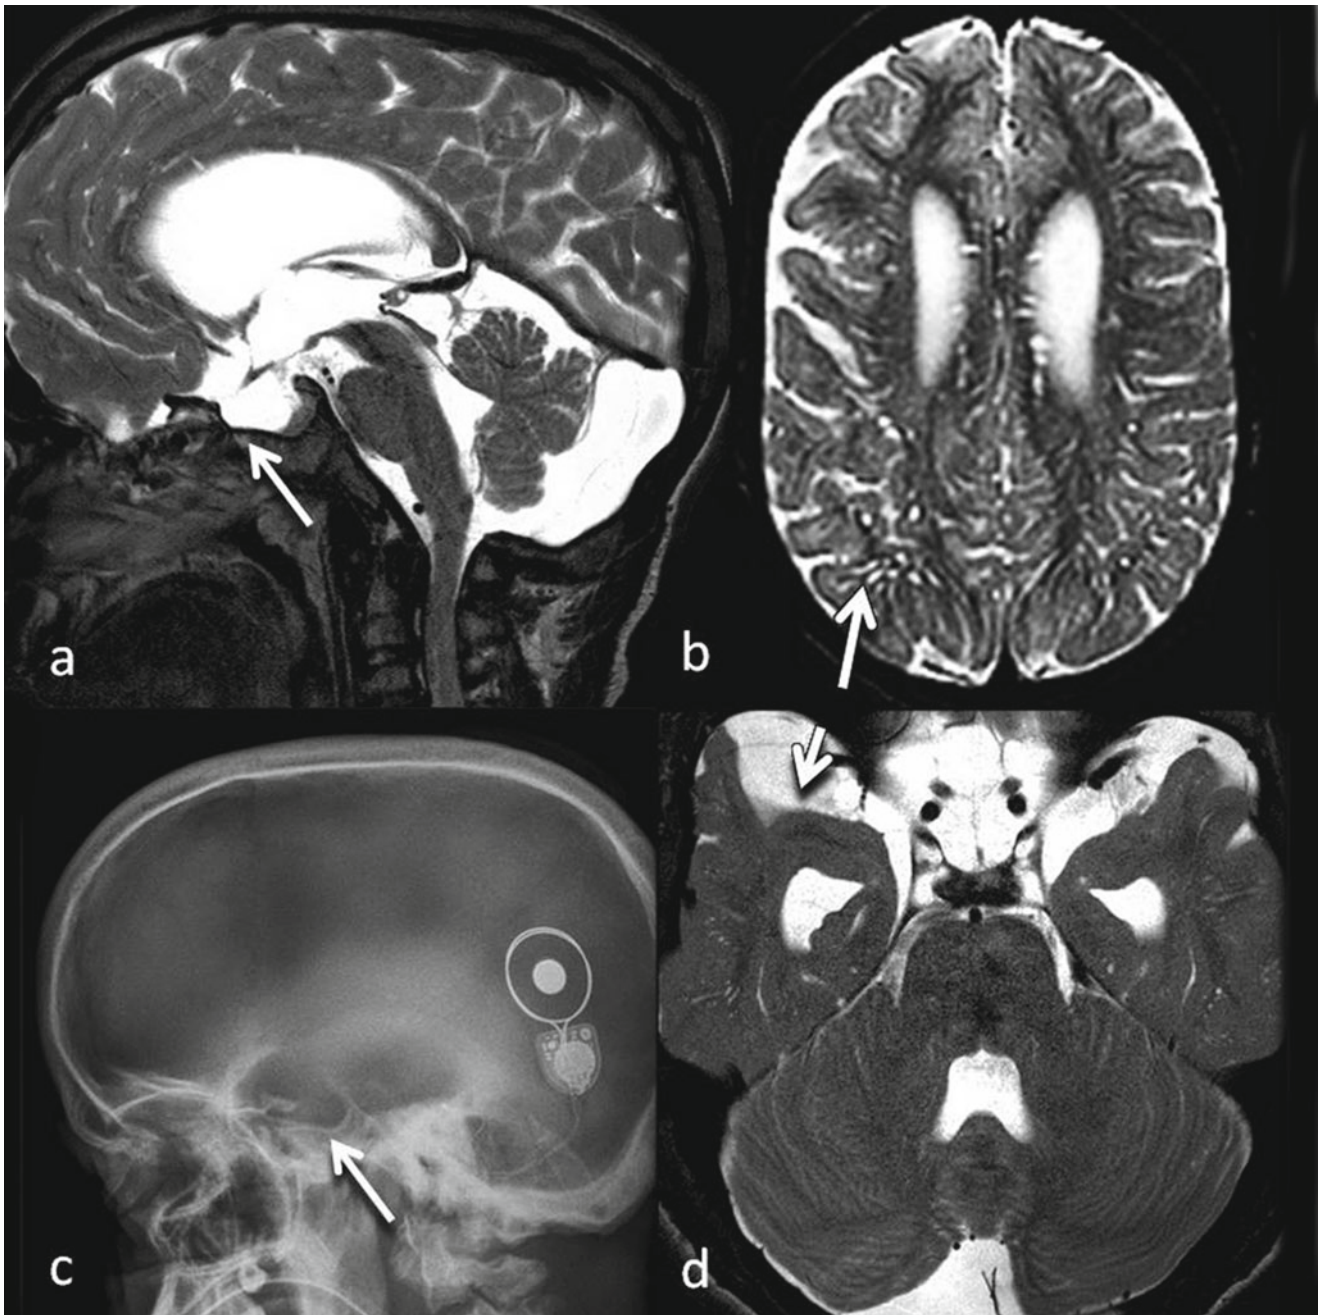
Examples of abnormal imaging findings that occur in mucopolysaccharidosis type 2. (a) MR sagittal T2 image and (c) lateral radiograph show thickened calvarium and an enlarged sella turcica
